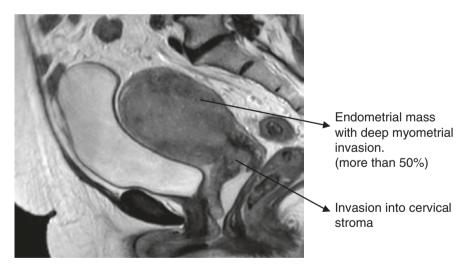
MRI showing deep myometrial invasion and cervical stromal involvement
